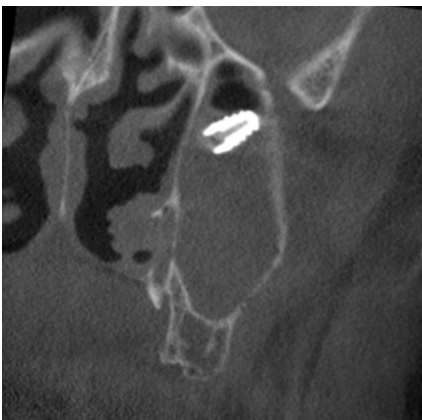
Coronal CBCT image at the distal aspect of the maxillary sinus
